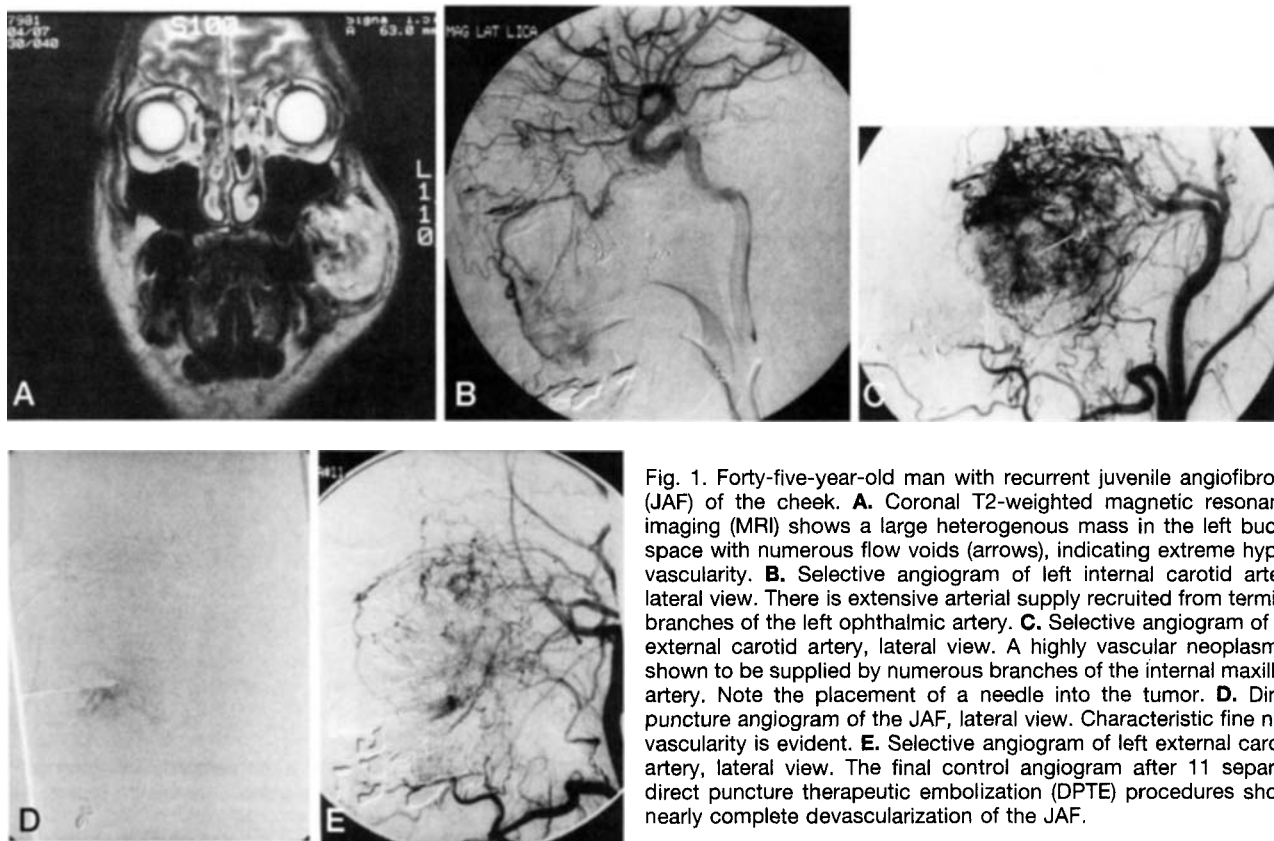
Forty-five-year-old man with recurrent juvenile angiofibroma (JAF) of the cheek. A. Coronal T2-weighted magnetic resonance imaging (MRI) shows a large heterogenous mass in the left buccal space with numerous flow voids (arrows), indicating extreme hyper-vascularity. B. Selective angiogram of left internal carotid artery, lateral view. There is extensive arterial supply recruited from terminal branches of the left ophthalmic artery. C. Selective angiogram of left external carotid artery, lateral view. A highly vascular neoplasm is shown to be supplied by numerous branches of the internal maxillary artery. Note the placement of a needle into the tumor. D. Direct puncture angiogram of the JAF, lateral view. Characteristic fine neovascularity is evident. E. Selective angiogram of left external carotid artery, lateral view. The final control angiogram after 11 separate direct puncture therapeutic embolization (DPTE) procedures shows nearly complete devascularization of the JAF.
